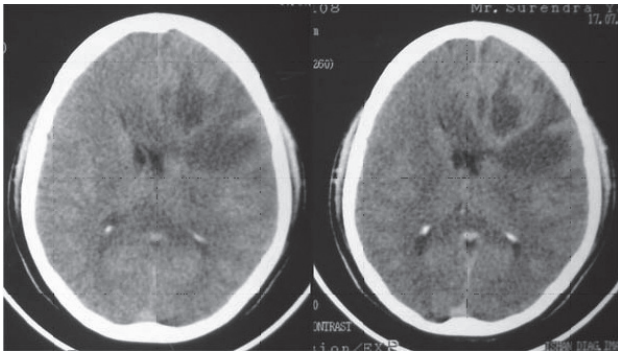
CT scan of case 1 showing mixed density lesion involving left frontal lobe with mass effect (left), lesion was enhancing after contrast administration (right).
